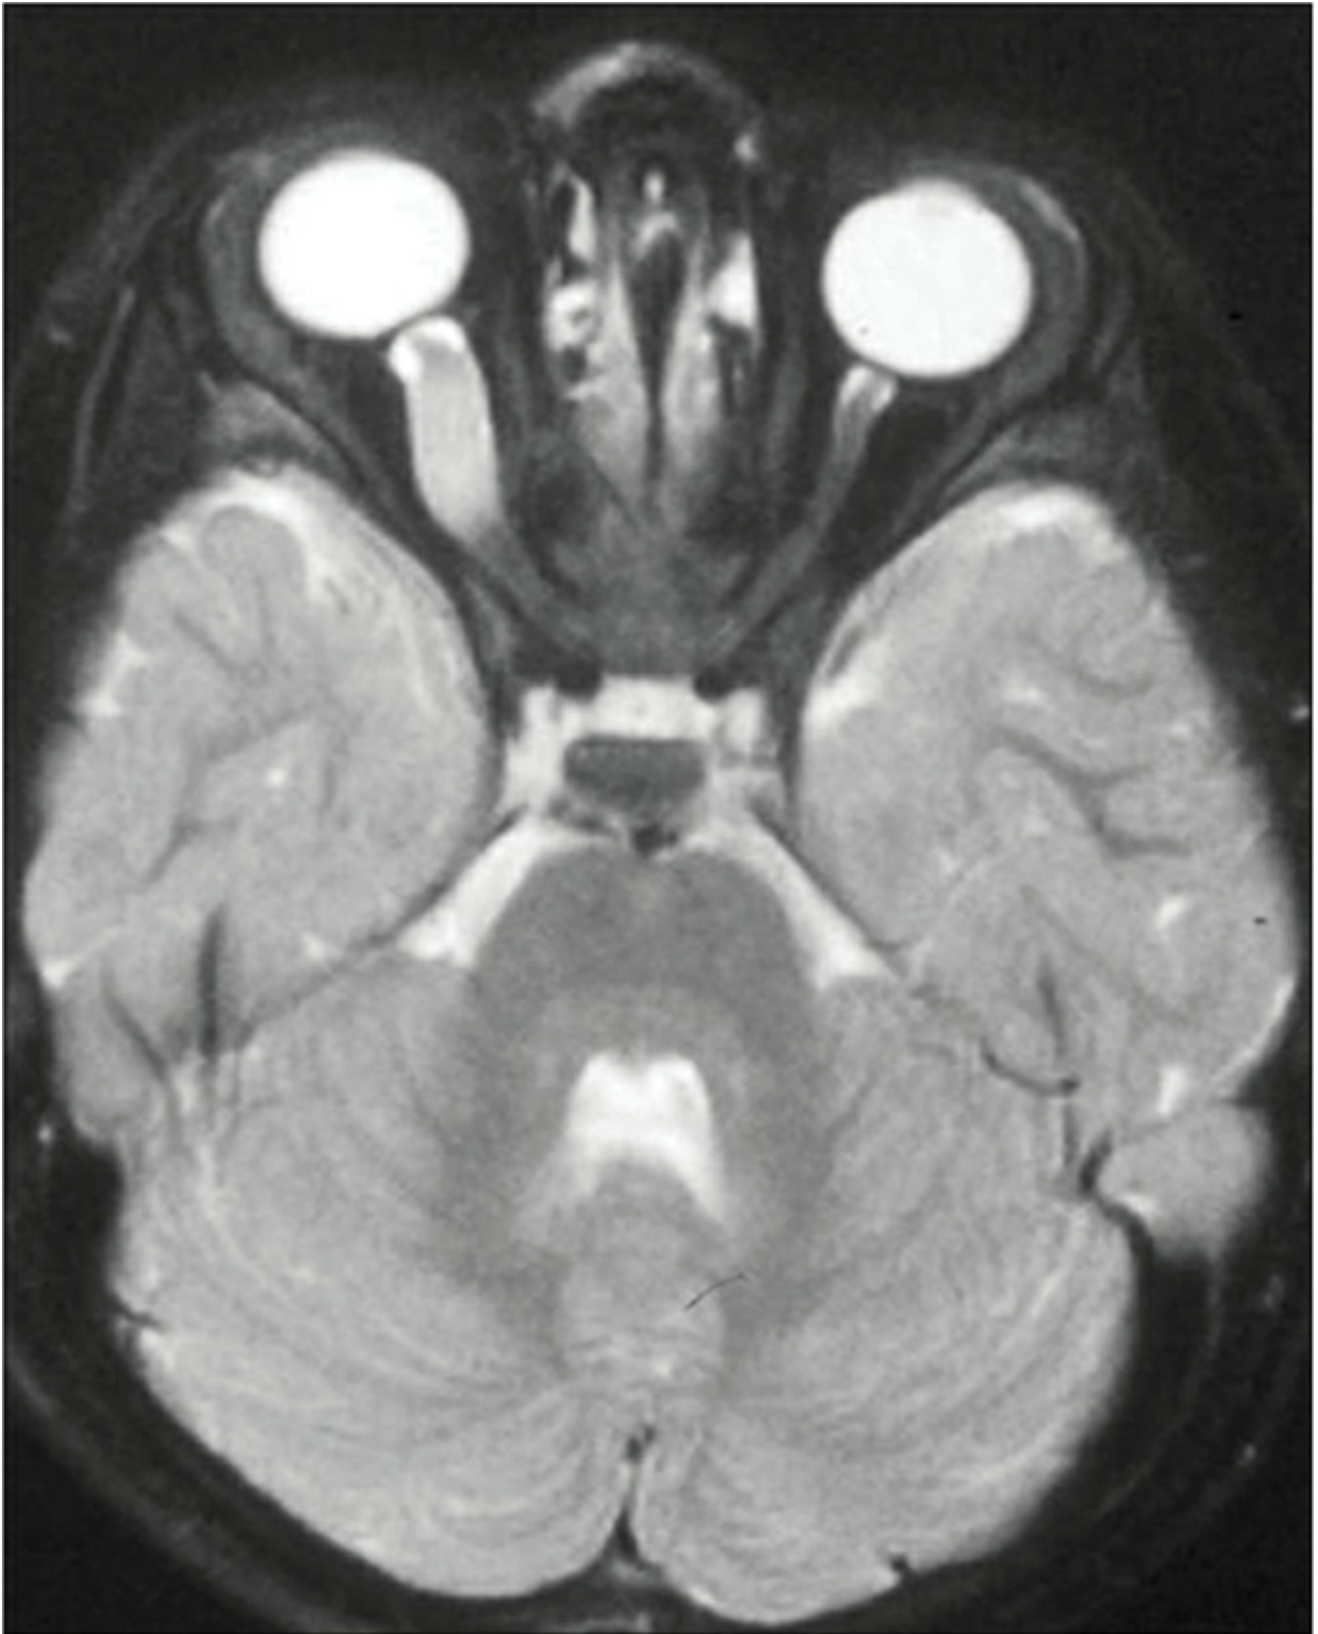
Axial MR image of a right optic pathway glioma in a child with NF1. (Courtesy of Ken K. Nischal, MD.)
